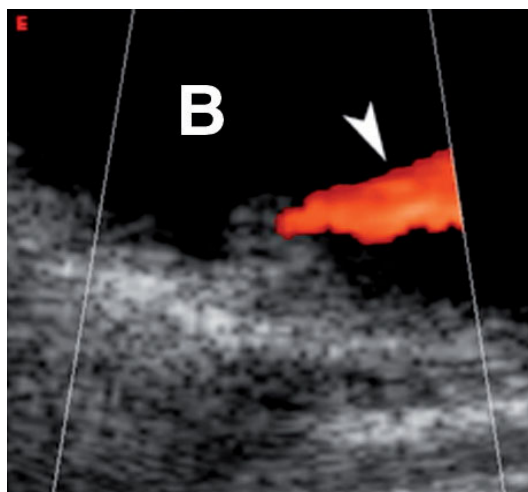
Ultrasonography. With the use of the color module a jet from the urethral meatus can be identified (*arrowhead*). *B*, urinary bladder
